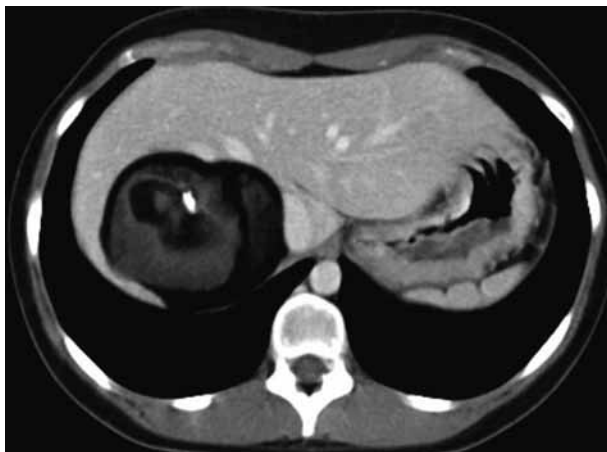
Abdominal CT scan (portal phase) showed a well defined lesion in the posterior right lobe of the liver. The lesion was a combination of fat, calcification and soft tissue components, with no enhancement after intravenous contrast administration.
